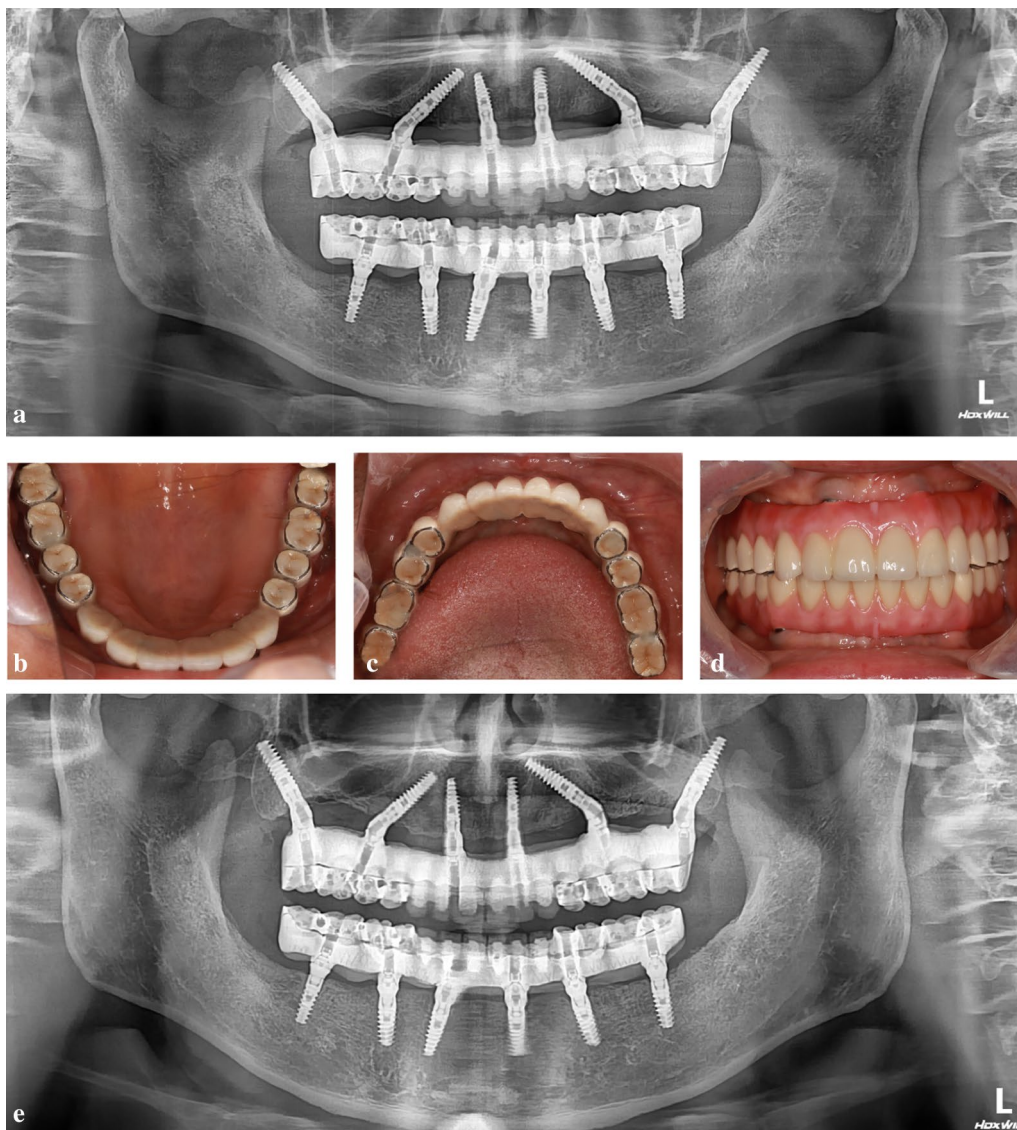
A B C D Panoramic radiograph and clinical view after 6 months. E A panoramic radiograph after 18 months
